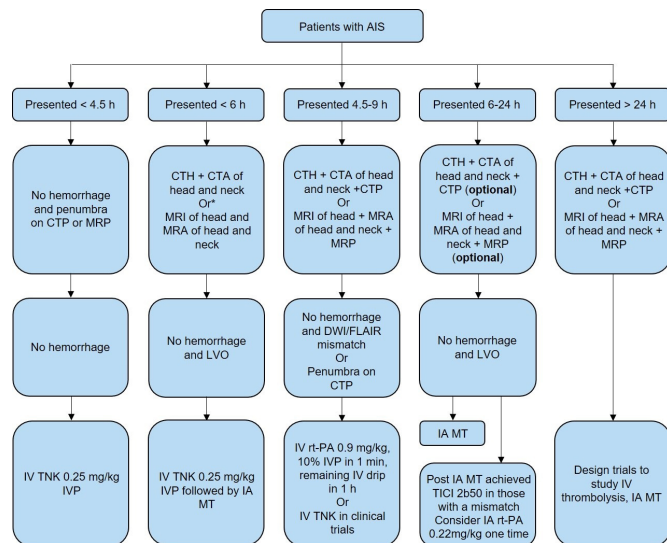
New proposed algorithm in AIS workup and treatment. *When IV contrast cannot be used. AIS, acute ischaemic stroke; CTA, CT angiogram; CTH, CT of head; CTP, CT perfusion; IA, intra-arterial; IV, intravenous; IVP, intravenous push; MRA, magnetic resonance angiogram; MRP, magnetic resonance perfusion; MT, mechanical thrombectomy; rt-PA, recombinant tissue plasminogen activator; TICI, thrombolysis in cerebral infarction; TNK, tenecteplase.
